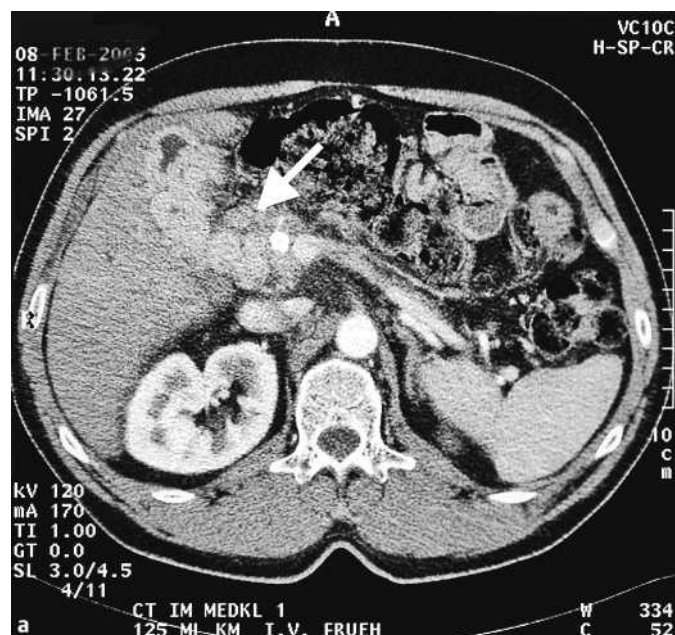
Patient 2. a Computed tomography showed multiple large venous collaterals (arrow) in proximity to the biliary system. b At endoscopic retrograde cholangiography, a fistula (arrow) was seen extending from the bile duct at the proximal edge of the stent into the cavernous vessels; the stent is blocked by a balloon catheter. At the same time, the common hepatic duct is not visualized. c Echocardiography: subcostal view with characteristic pattern of massive air embolism. Note the substantial acoustic shadowing adjacent to the right ventricular free wall (arrow).
